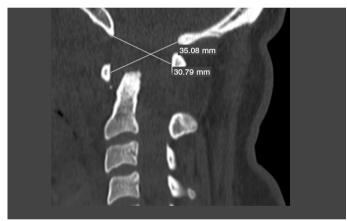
CT of the cervical spine, sagittal section. Measurements for the calculation of the Power's ratio, yielding a value of 0.87.
